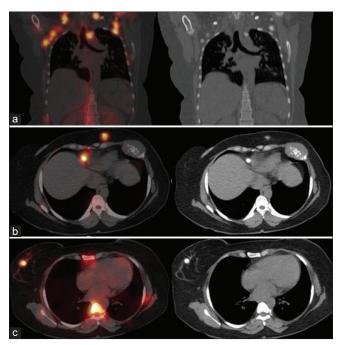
Transaxial sections of hybrid single-photon emission computed tomography/computed tomography and corresponding computed tomography images of the thoracic region (a-c) showing tracer avid diffuse calcified deposits in bilateral cervical, supraclavicular, and axillary lymph nodes; (a), anterior chest wall in the form of subcutaneous nodule and paracardiac lymph node; (b), right breast; (c)
